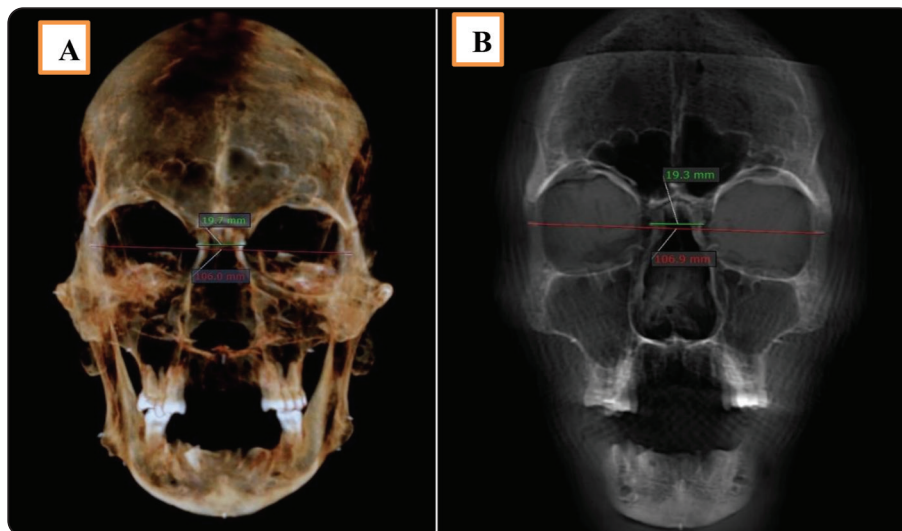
A) Radiograph from the 3DVR showing Linear measurements of the bi-orbital width (LOR- LOL) (red line) and the inter-orbital width (MOR-MOL) (green line) from the facial skull view B) Radiograph from MPR showing Linear measurements of inter-orbital width (MOR-MOL) (green line) and bi- orbital width (LOR- LOL) (red line) from the coronal plane.
